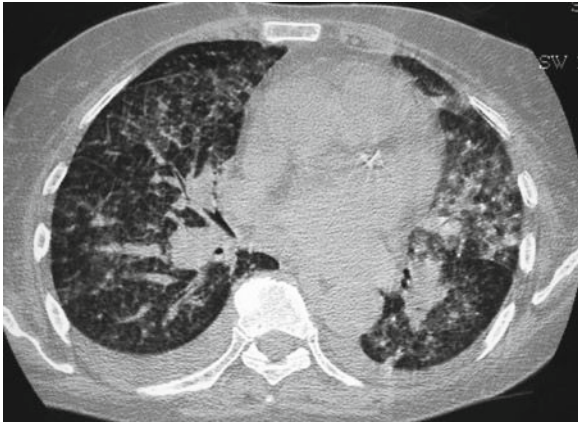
CT scan aspect of histoplasmosis in a patient at the accelerated phase of chronic myelogenous leukemia
